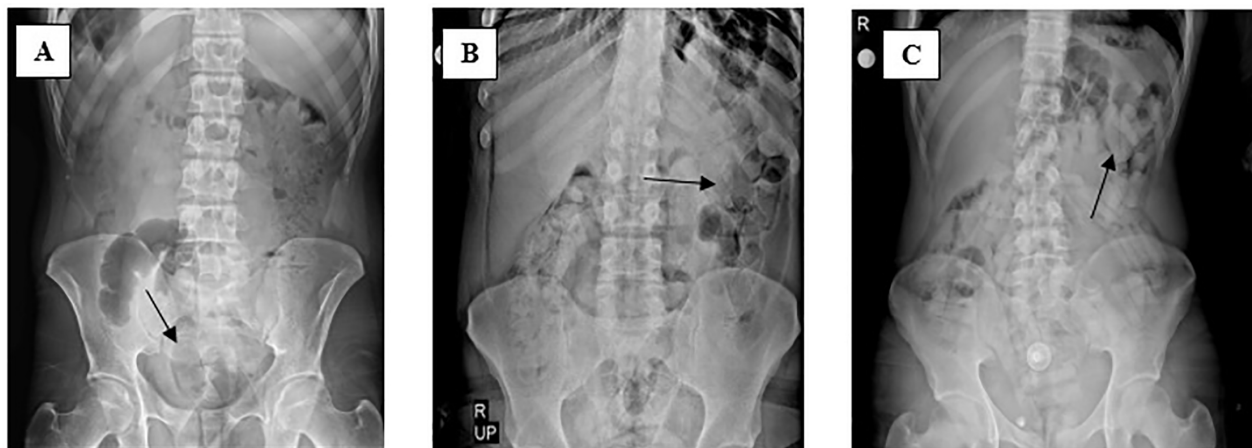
X-ray images of cases carrying drug packages in their bodies: Case 2 (A), Case 7 (B), and Case 9 (C) (black arrow: Shows packages)
